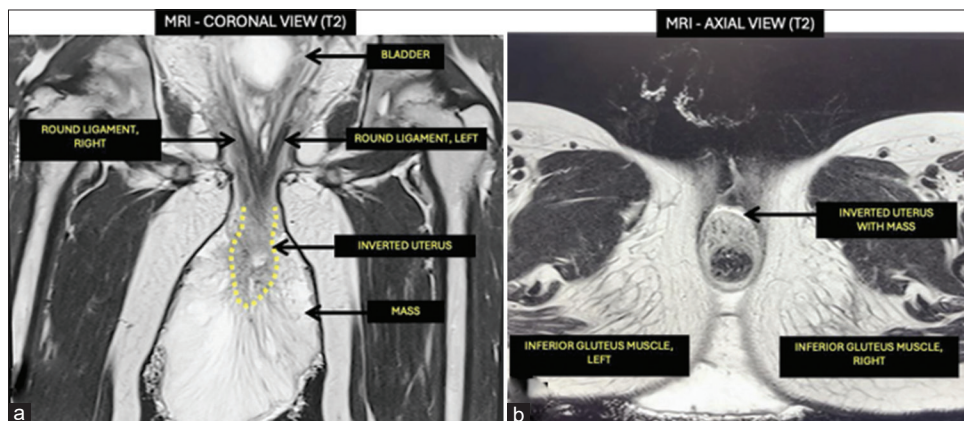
Magnetic resonance imaging images. (a) Coronal view showing an inverted uterus with prolapsed mass. Superior to the uterus are the round ligaments pulled medially toward the inverted uterus. (b) Axial view showing an inverted uterus with bull's eye or target appearance which is pathognomonic of uterine inversion
